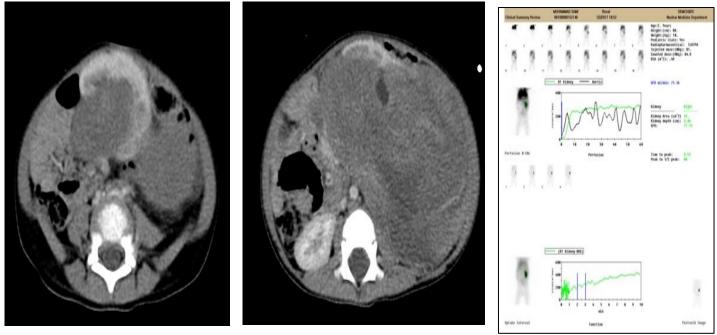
(a,b) Axial contrast enhanced CT images showing heterogeneously enhancing mass with internal cystic change arising from left renal medulla, right kidney is normal (c) Renogram image with no visualization of left kidney.
